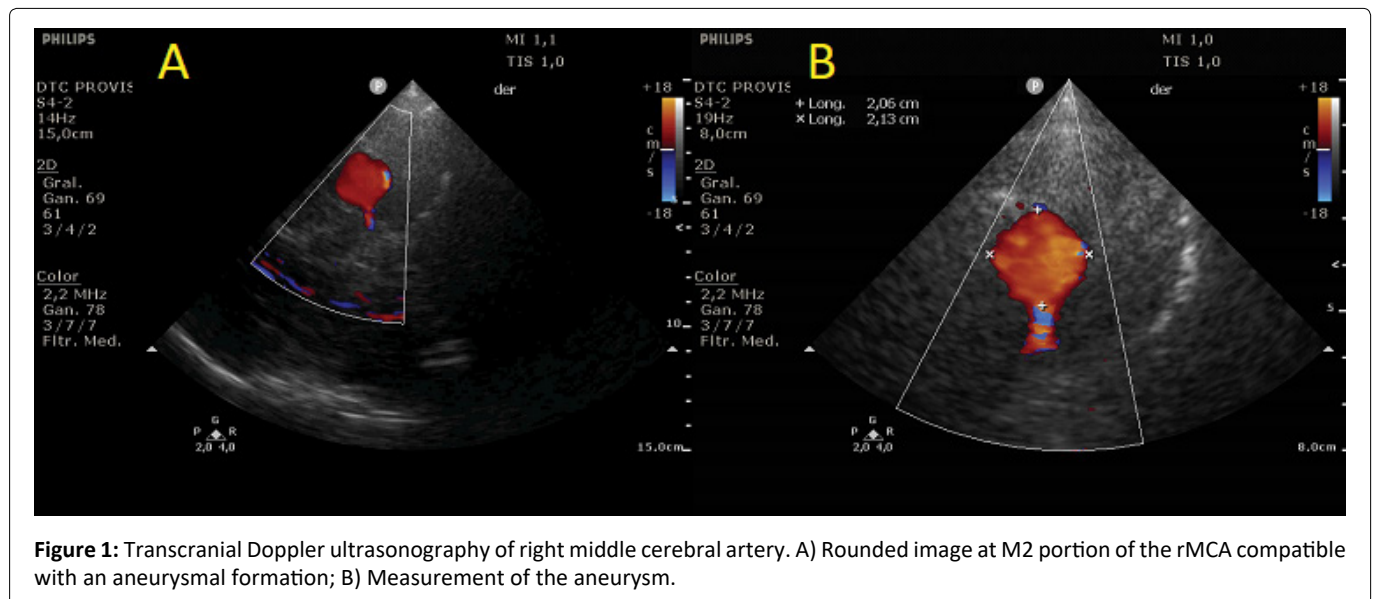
Transcranial Doppler ultrasonography of right middle cerebral artery. A) Rounded image at M2 portion of the rMCA compatible with an aneurysmal formation; B) Measurement of the aneurysm.
